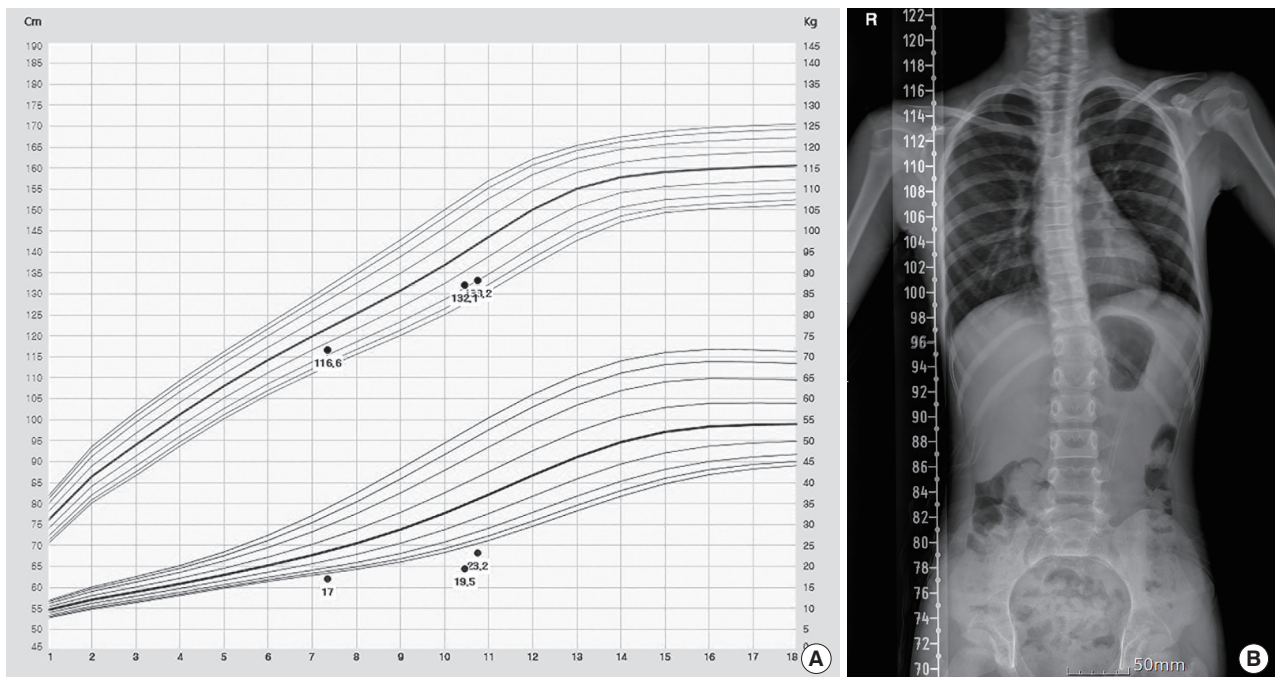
The growth curve (A) and X-ray findings (B) of a 10-year-old Korean girl with 16p11.2 duplication syndrome. Her height was within the 5-10th percentile (upper curve) and her weight was under the 3rd percentile (lower curve) showing poor weight gain and failure to thrive (A). The radiological findings suggested right thoracolumbar scoliosis with an apex at T12 and a Cobb angle of 6° (B).
